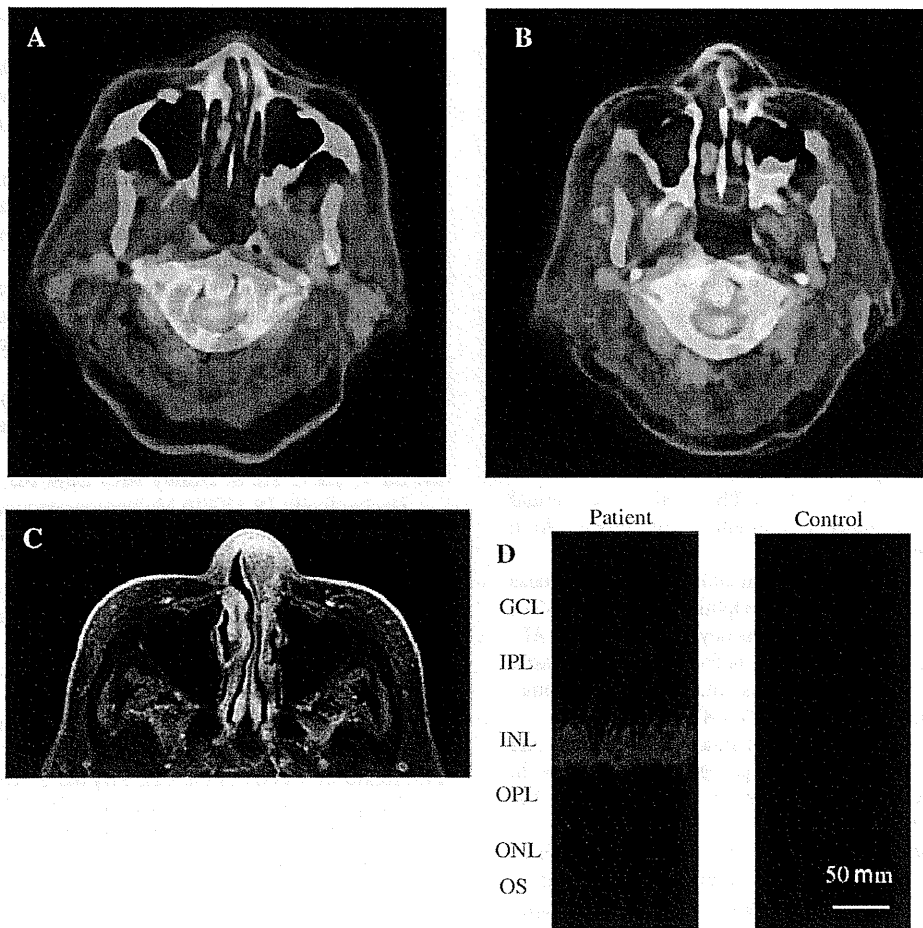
a Positron emission tomography (PET)–computed tomography (CT) could not find abnormal signs in December 2009. b PET-CT showed abnormal accumulation of ^{18}F -fluorodeoxy glucose in the left nasal cavity in May 2010. c A tumor in the left nasal cavity was identified by MRI in May
